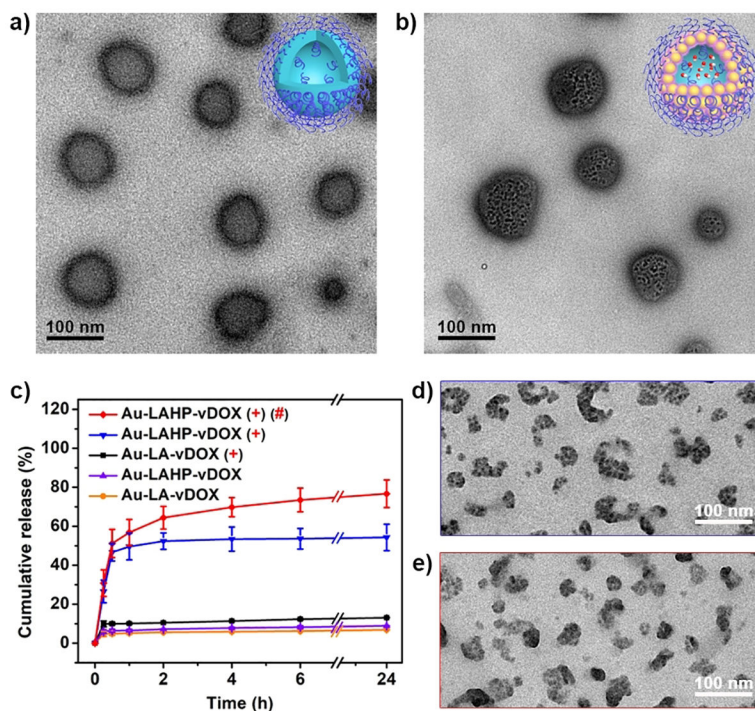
TEM images of (a) PPS-PEG only and (b) Au-LAHP-vDOX vesicles. (c) Cumulative drug releasing profiles of the vesicles under different conditions. (+) represents that samples were applied with X-ray irradiation (8 Gy) and incubated with PBS (1×), (#) represents that sample was incubated with H₂O₂ (100 μM). TEM images of Au-LAHP-vDOX incubated with (d) PBS (1×) and (e) H₂O₂ (100 μM) after X-ray irradiation, respectively.
